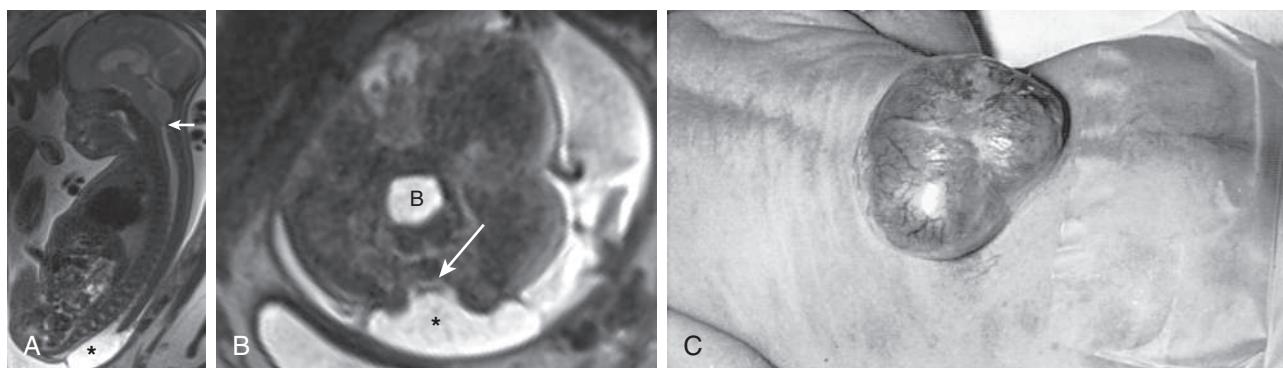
Typical MRI imaging and physical exam findings of a lumbosacral myelomeningocele. A, Single-shot sagittal T2-weighted image of a fetus at 28 wk gestation demonstrates a lumbosacral spinal defect with protruding myelomeningocele sac (asterisk) and herniation of the brainstem/cerebellum into the upper spinal canal, a Chiari II malformation (arrow). B, Single-shot axial T2-weighted images of the same fetus at the level of the myelomeningocele demonstrates a neural placode (arrow) at the base of the myelomeningocele sac (asterisk). Urinary bladder marked with B. C, A lumbar myelomeningocele is covered by a thin layer of skin.
